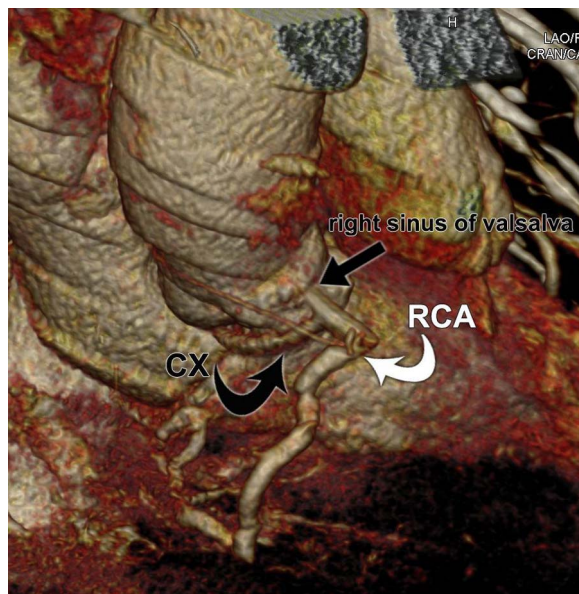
Right oblique superior three-dimensional volume-rendered CT image demonstrates the anomalous origin of the left circumflex coronary artery (curved black arrow) from the right coronary artery (curved white arrow). There is 3 mm long common trunk arising from the right sinus of Valsalva (small arrow) that bifurcates into the left circumflex and right coronary arteries. CX, coronary artery; RCA, right coronary artery.
